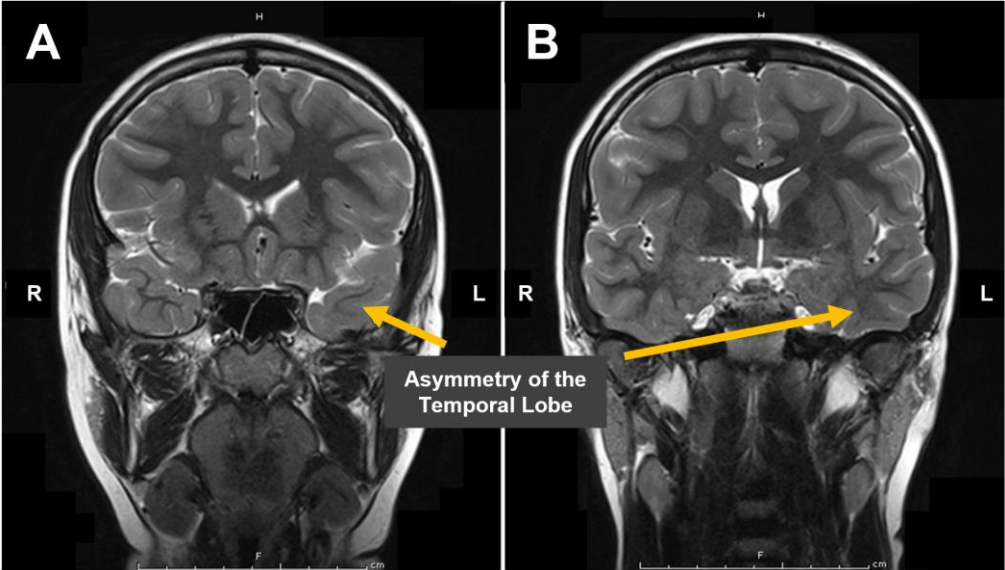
MRI of a 12 year old patient from the intracranial electroencephalography study, later described in this paper, with a smaller left temporal lobe than the right; A) arrow points to the asymmetry located in the left area of the temporal lobe; B) another MRI slice of the same asymmetry.
